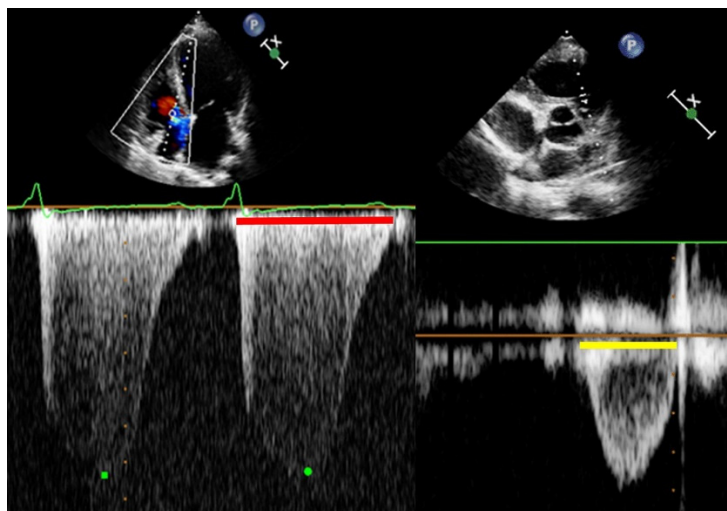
On the left continuous doppler registration of the tricuspid regurgitation and on the right pulsed waved doppler from the right ventricular outflow tract. Registrations of tricuspid valve ejection time (TVET) indicated by red line and right ventricular ejection time (RVET) indicated by yellow line are used to calculate right index of myocardial performance (RIMP) through the following formula: $(TVET-RVET)/RVET$.
